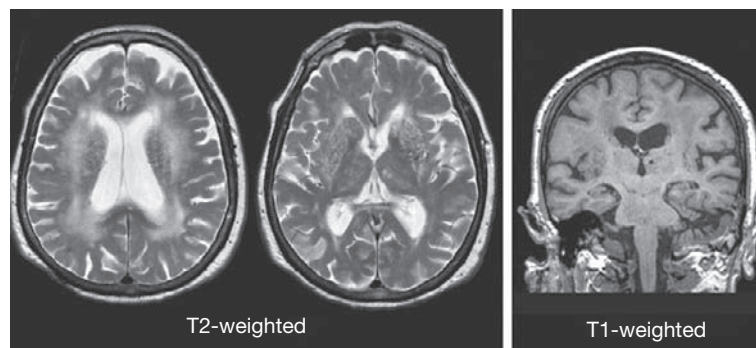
Vascular dementia. Shown are axial T2-weighted and coronal T1-weighted images from an 80-year-old woman with impairment of cognition and gait. Note the thalamic infarctions and the large areas of altered signal (increased on T2 and decreased on T1) in the centrum semiovale.
